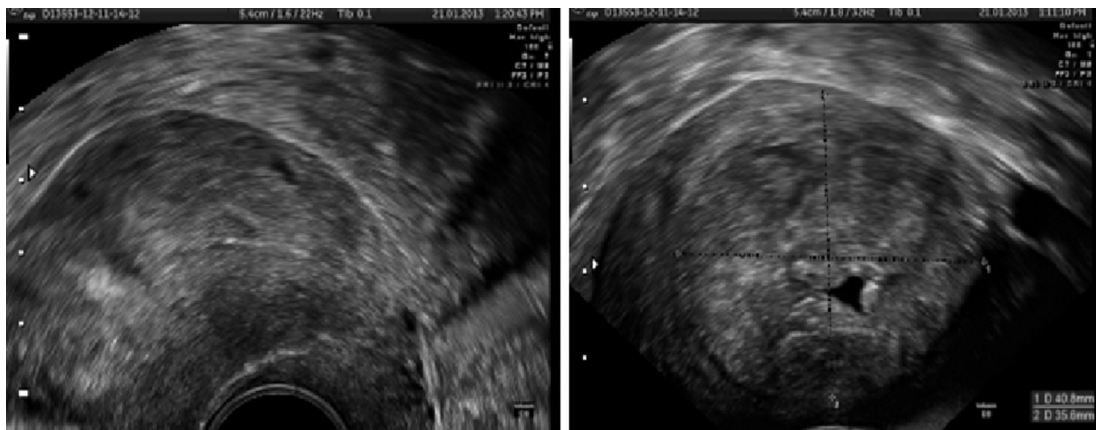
Sonographic pictures: interstitial pregnancy.
